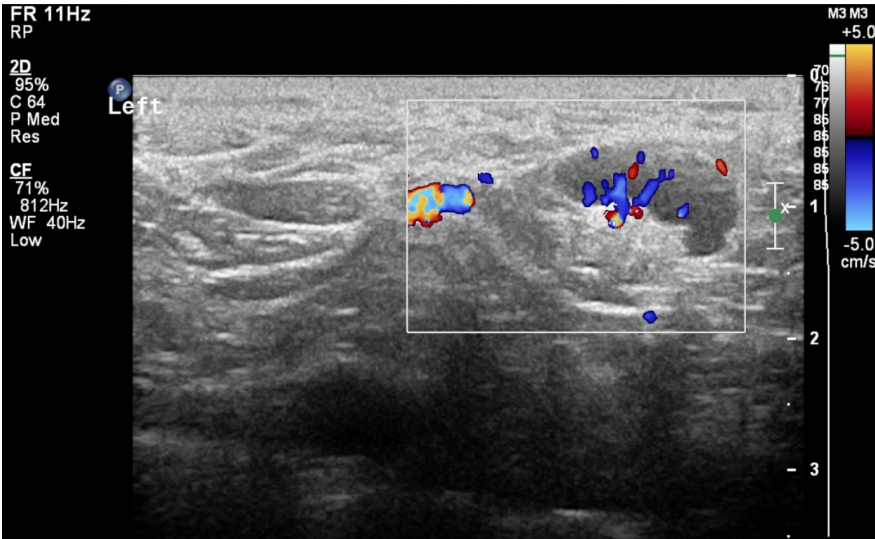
Ultrasound scan of patient number 12 showing an 8.2mm slightly hypoechoic lymph node in the left supraclavicular region with increased vascularity on colour doppler.
